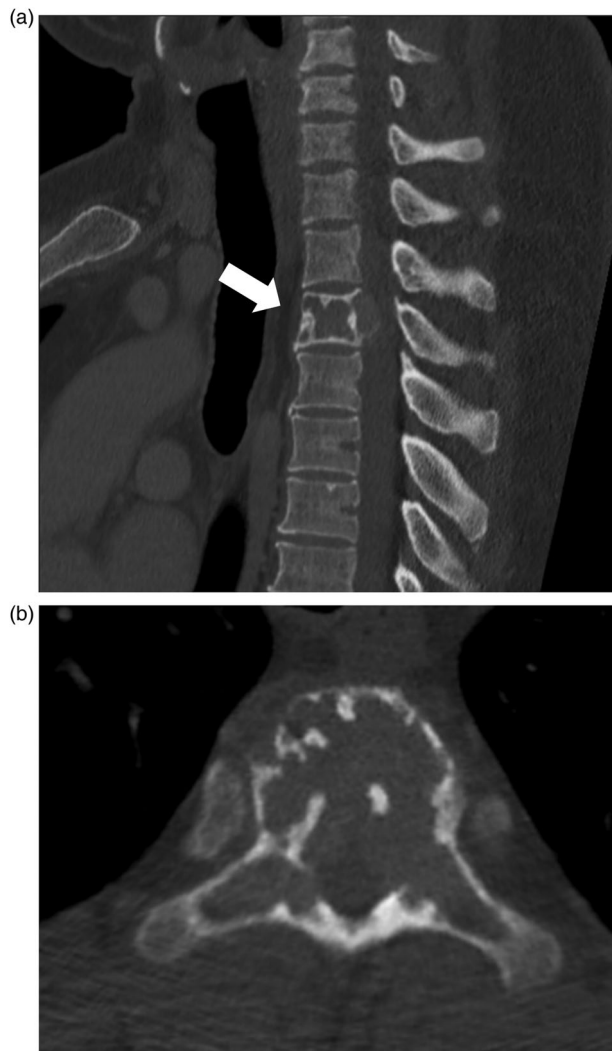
(A) CT sagittal view of the thoracic spine, showing a spinal tumor at the T3 vertebral body expanding into the spinal canal (arrow). (B) CT axial view of the thoracic spine, showing a multilocular and expanding lytic lesion in the vertebral body and bilateral transverse process.
